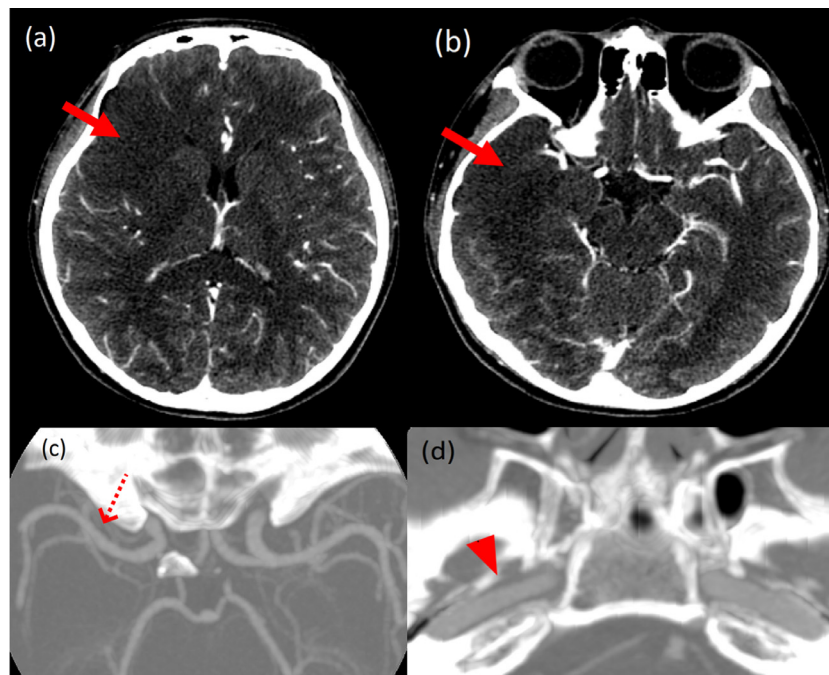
CT brain with cerebral angiogram demonstrating loss of gray-white differentiation (red arrows) in the right frontal (A) and anterior temporal lobe (B) with involvement of the basal ganglia consistent with acute infarcts in the right MCA territory. Maximum-intensity projection (MIP) demonstrating the patency (red dashed arrow) of the right proximal MCA (C) and petrous segment of the right ICA (D). Note the relative reduction of the right ICA (red arrowhead) compared to the contralateral left side.
